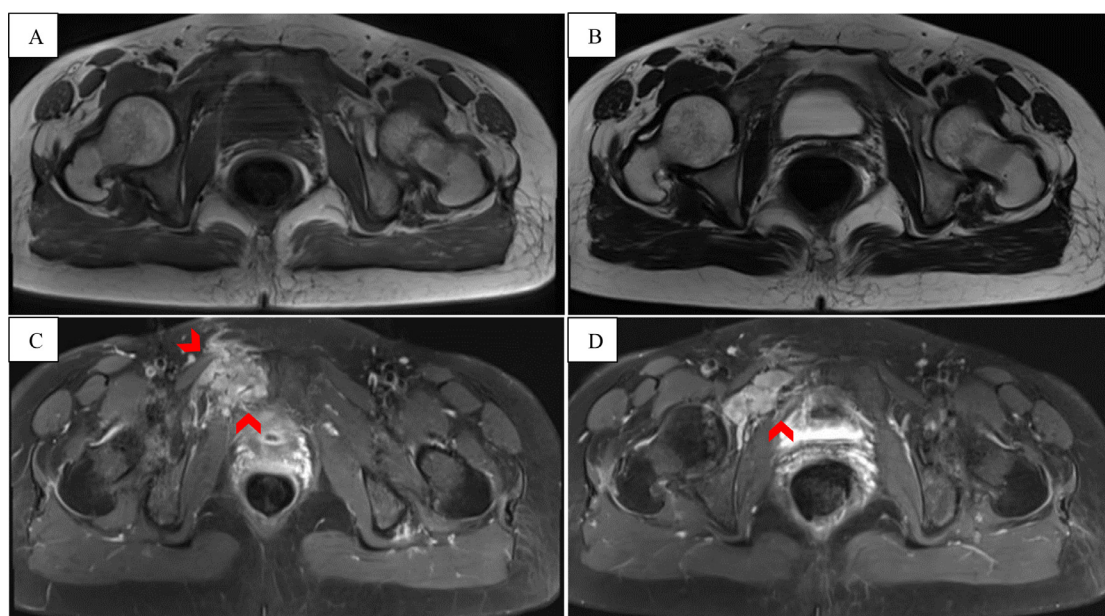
On the MRI, these lytic bone lesions were hypointense on T1-weighted images (A), hyperintense with some areas of hypointense on T2-weighted images (B), and showed heterogeneous contrast enhancement (arrowheads, C and D).
